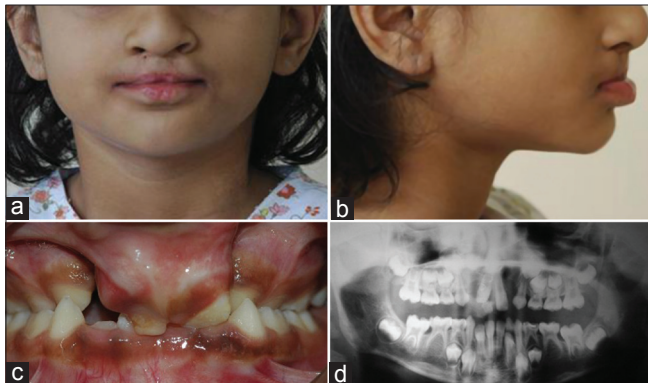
(a) Pre-treatment extraoral frontal view, (b) Pre-treatment extraoral profile view, (c) Pre-treatment intraoral frontal view, (d) Pre-treatment orthopantomograph
